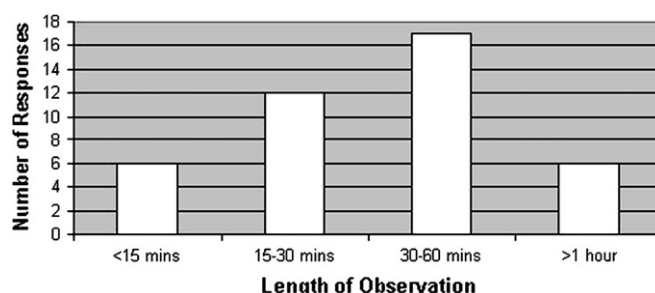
Length of observation for patients who received anxiolytic medication after completion of MRI scan.
